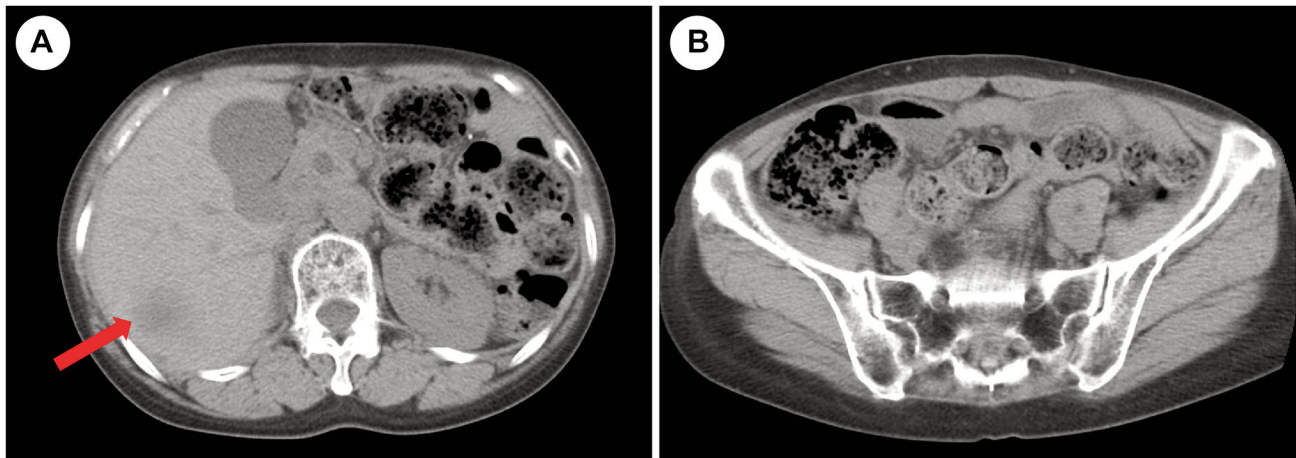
Plain computed tomography findings of the abdomen and pelvis at the initial visit: A: Hepatic cyst (red arrow). B: No recurrent lesions in the pelvis after total gastrectomy.
